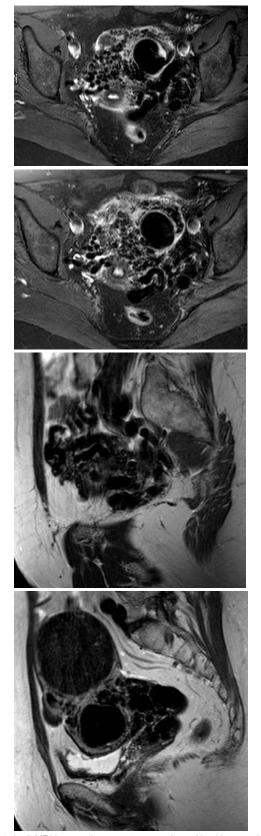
(a-d) MRI images demonstrate a very large 11 x 11 cm uterine AVM with numerous T2 hypointense flow voids consistent with dilated vascular channels.
